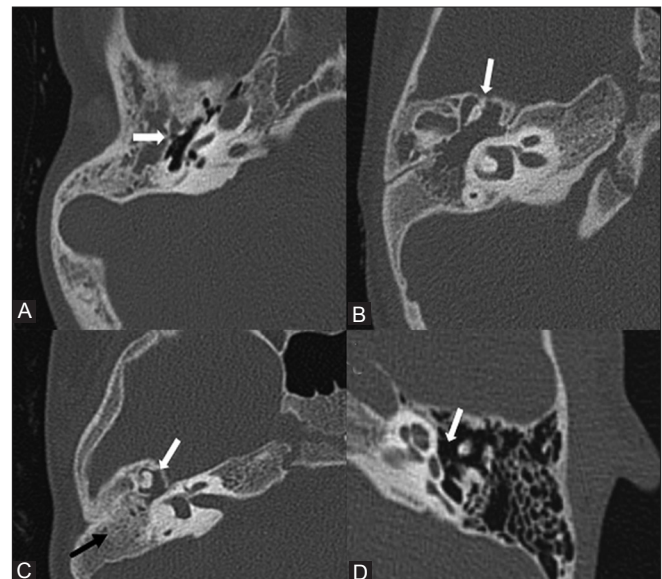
(A-D): Middle ear anomalies. (A) Axial HRCT section shows small capacity middle ear (arrow). (B) Axial HRCT section shows dysplastic malleus and incus. Also note an associated cholesteatoma. (C) Axial HRCT section shows incudomalleal ankylosis (white arrow). Also seen is non-pneumatized atretic plate (black arrow). (D) Axial HRCT section in microtia shows normal stapes
